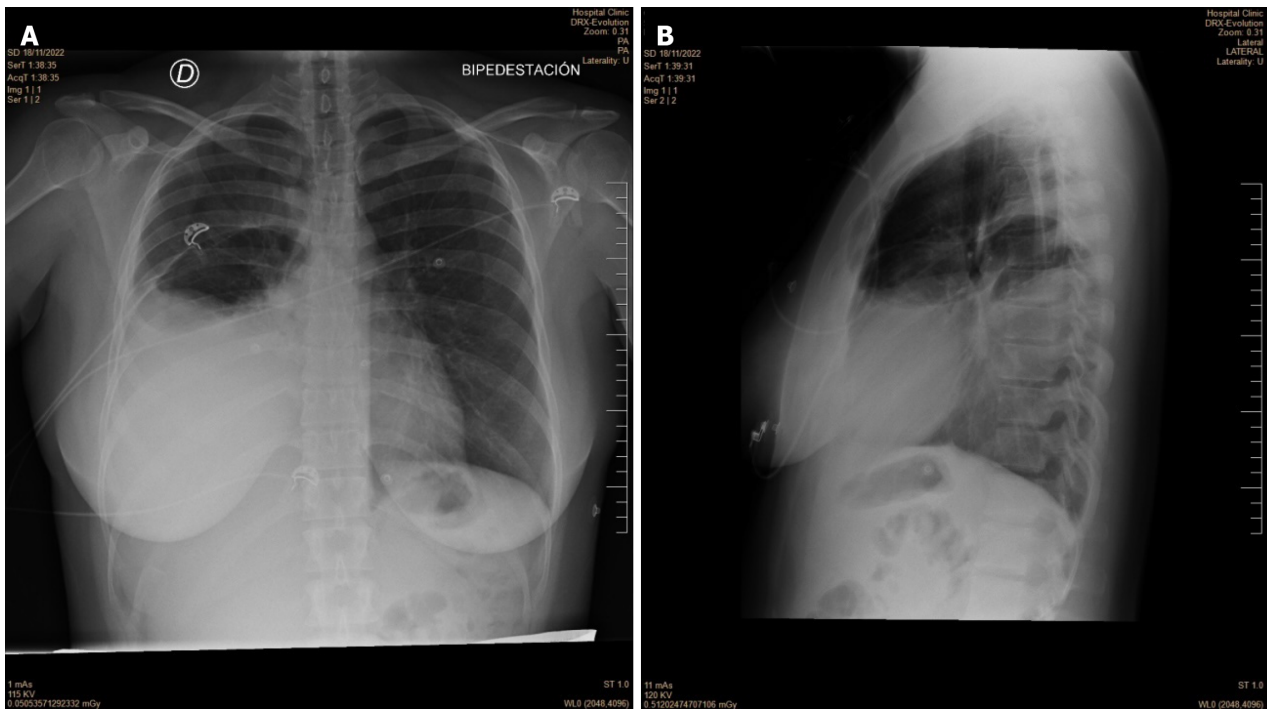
Chest X-ray upon admission (November 18, 2022) showing right pleural effusion. A: Erect anteroposterior view; B: Erect lateral view.
